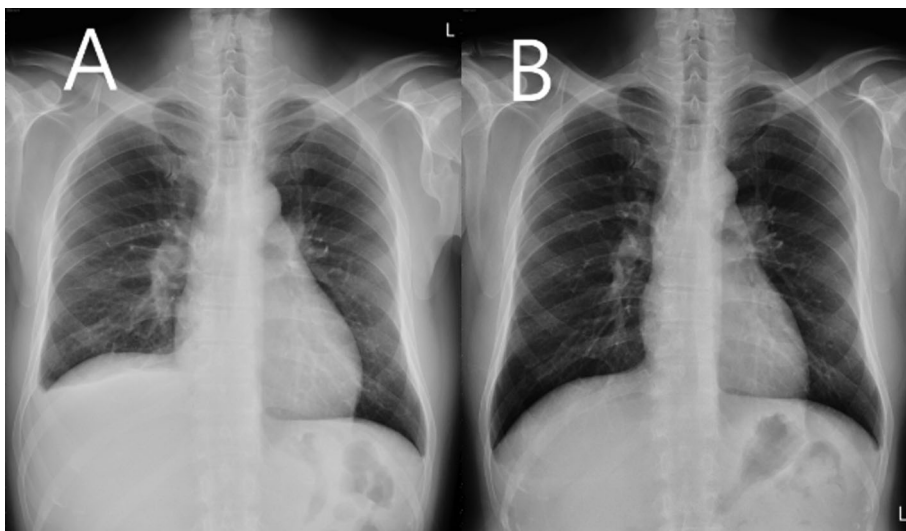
Improvement of pleural effusion on chest plain films. (A) Chest radiograph showed bilateral pleural effusion, especially in the right hemithorax, with the treatment of dasatinib. (B) Chest radiograph showed no recurrence of pleural effusion after the replacement of dasatinib by nilotinib.
